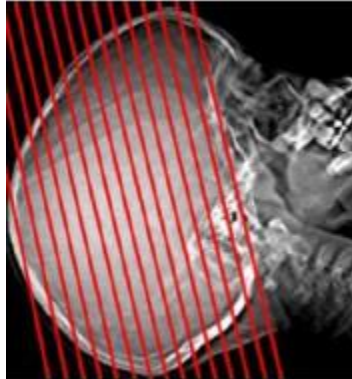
CT scan of the head
